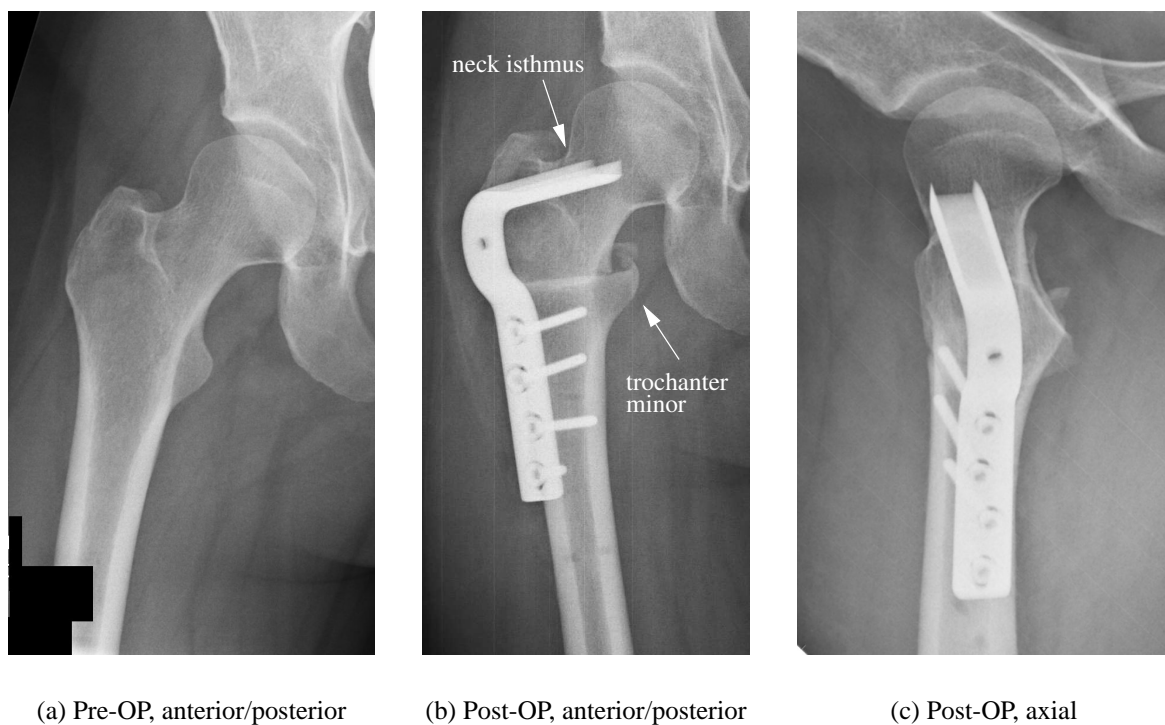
X-ray images of a patient who was treated with the conventional technique
